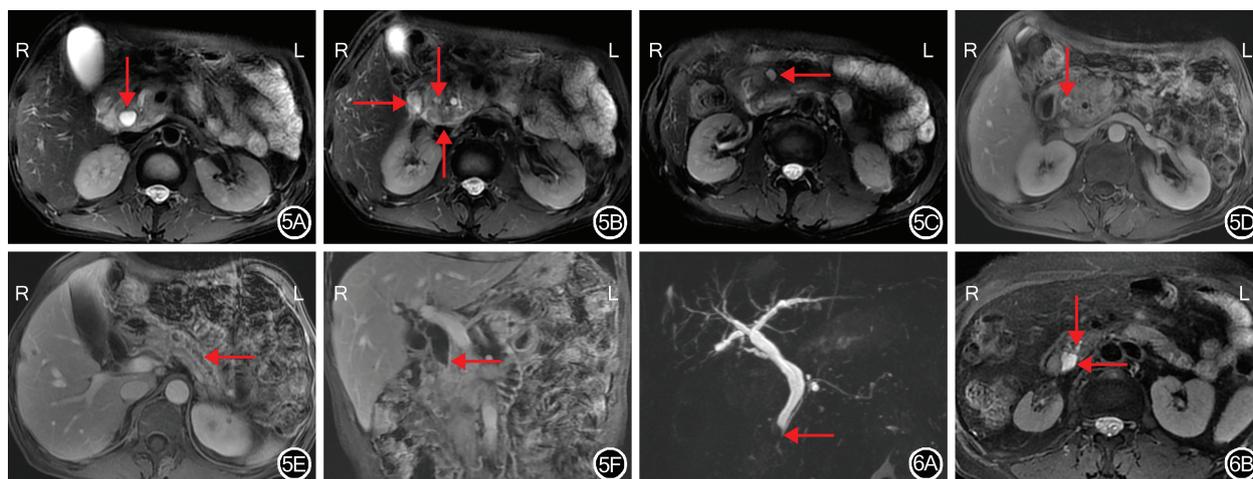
62 岁男性沟槽状胰腺炎患者的影像学检查结果 5A: MRI 检查 T2 加权成像抑脂序列示胆总管扩张(↓); 5B: MRI 检查 T2 加权成像抑脂序列示沟槽区不均匀片状肿物, 边界不清晰, 累及十二指肠及胰头(↑), 十二指肠肠壁增厚(→), 胆总管突然狭窄、变细(↓); 5C: MRI 检查 T2 加权成像抑脂序列示肿块内可见囊性病灶(←); 5D: MRI 检查增强扫描 T1 加权成像抑脂序列示肿块呈持续不均匀强化, 胆总管明显狭窄并管壁增厚(↓); 5E: MRI 检查增强扫描 T1 加权成像抑脂序列示胰管不均匀扩张(←); 5F: MRI 检查增强扫描 T1 加权成像抑脂序列冠状位示胆总管管壁增厚并呈外压性狭窄(←) 图 6 47 岁女性 Lemmel 综合征患者影像学检查结果 6A: MRCP 检查快速自旋回波厚层图像示胆总管远端突然变窄(←); 6B: MRI 检查 T2 加权成像抑脂序列示十二指肠降段内侧囊袋样结构(←), 胆总管受压变窄(↓)
